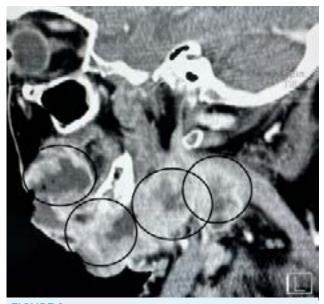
Skull CT scan - sagittal plane: tumor masses
